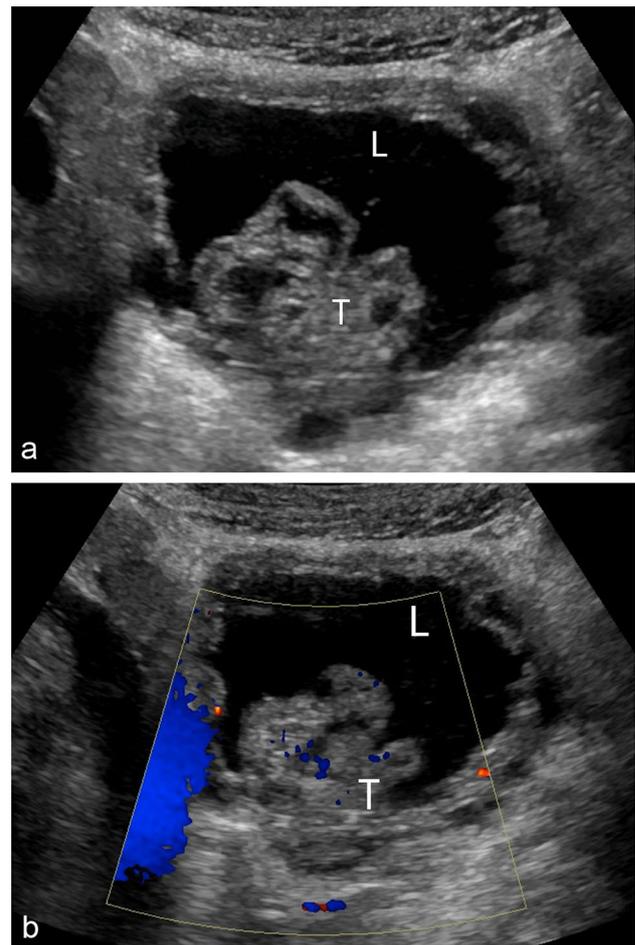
87-year-old male with large bladder thrombus. a Transverse ultrasound view of the bladder shows a heterogeneous lobulated mass, confirmed to represent a thrombus on cystoscopy. b Transverse ultrasound view of the bladder with color Doppler overlay. Scattered blue foci over the lesion are artifactual. No vascularity was present within the mass. *L* bladder lumen, *T* thrombus
